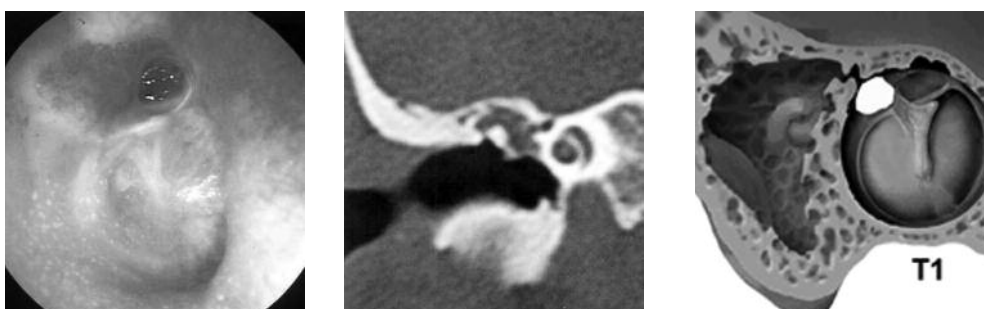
Otoloscopic and CT findings of case 1.
